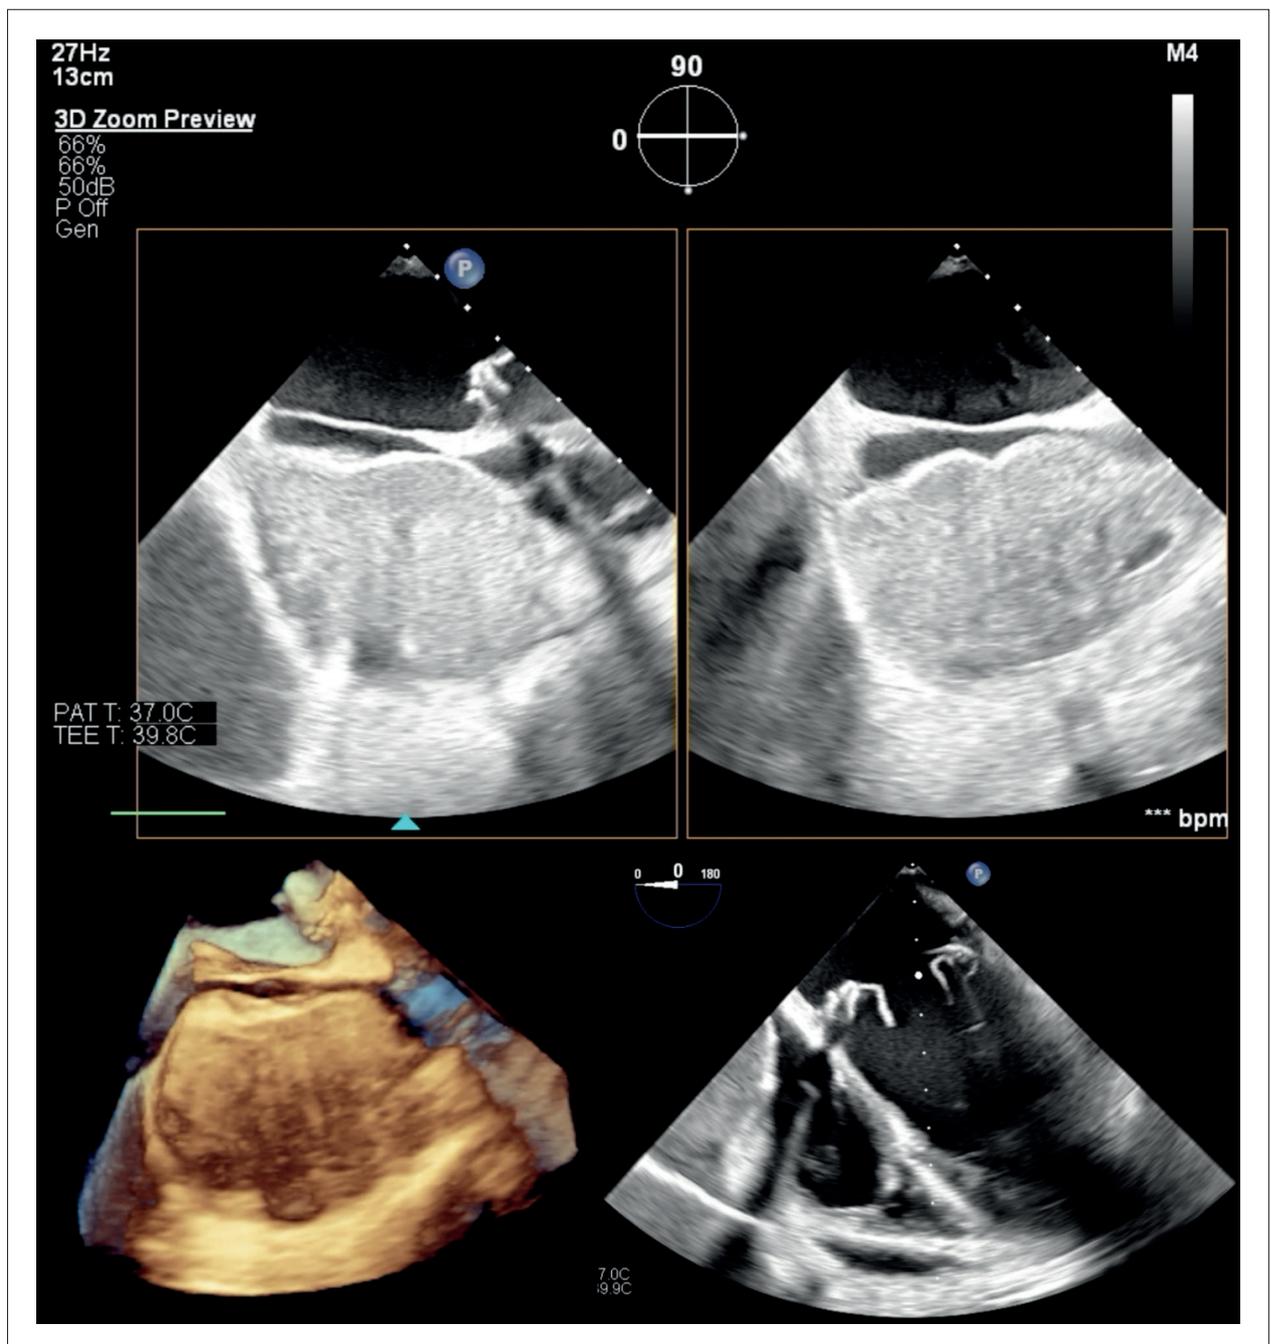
Three-dimensional Transesophageal Echocardiography reveals significant extrinsic compression of the right atrium caused by a large pericardial hematoma. In the top image, a biplane view at 0° and 90° in the mid-esophagus is shown. In the lower-left corner, the three-dimensional reconstruction highlights compression of the right atrium, restricting flow from the superior vena cava. On the right, a four-chamber view at 0° in the mid-esophagus demonstrates compression of the right atrium just above the tricuspid valve.
